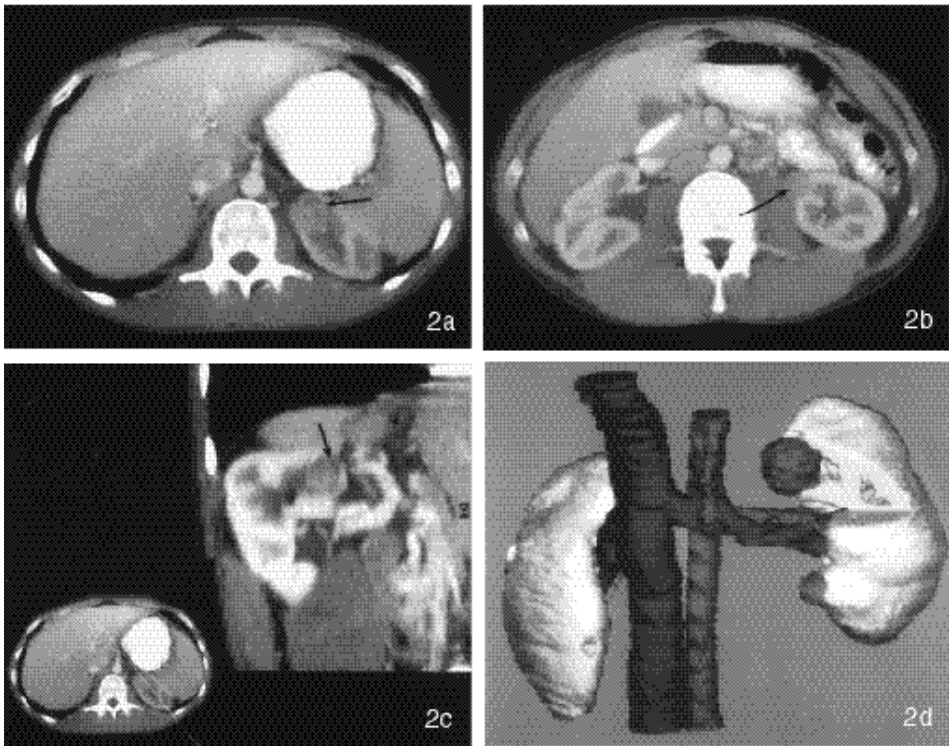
CT images of the kidneys in the corticomedullary phase after intravenous contrast shows small RCCs in the left kidney of a 30-year old VHL patient. a Lesion in the upper pole (arrow) measures nearly 3 cm. b Smaller lesion (arrow) in lower pole of the kidney. Both lesions appear to be encapsulated. Right kidney shows a small cortical cyst. c Oblique reconstruction and d coronal 3D surface rendering show the exophytic lesions emanating from the medial aspect of the kidney, free from the main renal vessels. In the upper pole the renal parenchyma has been partly cut away. The right kidney shows cortical defects caused by cysts (see b). Elective surgery could be performed on the left kidney. Encapsulated cystic tumours of 1.8 and 2.6 cm in diameter were removed radically. The larger tumour showed infiltration into the pseudocapsule, but did not penetrate it. Radiological follow-up (four years) showed enlarging cysts in right kidney, but no tumour in left kidney.
